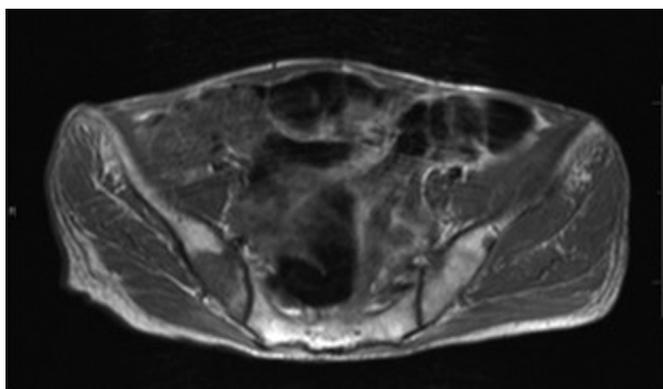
Magnetic resonance imaging of the pelvis showing an undisplaced left iliac wing fracture due to metastases.
